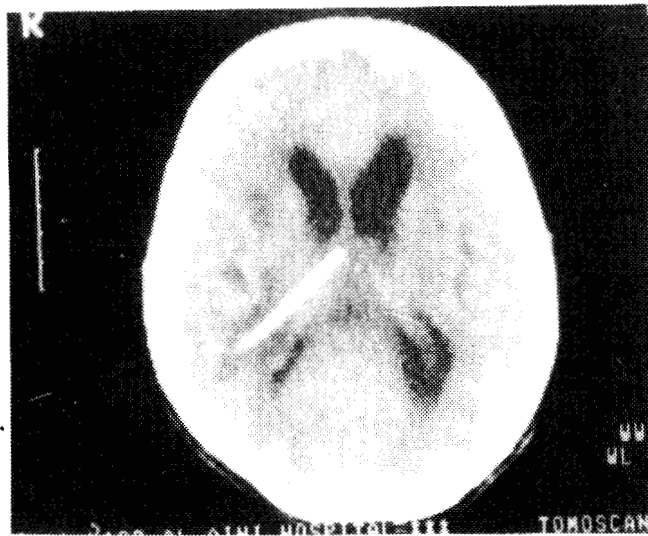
Post shunt CT head scan showing the change of degree of hydrocephalus to the mild form (same patient in fig. 4a).
